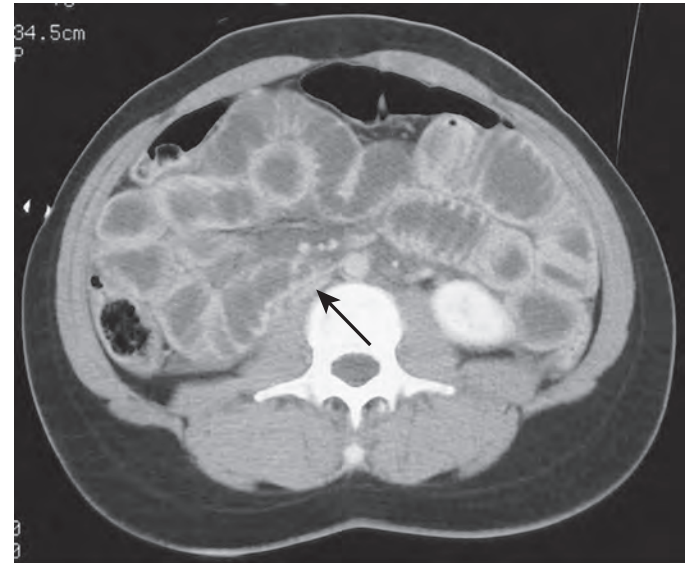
Shock bowel in a 23-year-old woman immediately after a motor vehicle accident. Contrast-enhanced CT demonstrates pneumoperitoneum, a flattened IVC (arrow) suggestive of hypovolemia, and a diffusely thickened, avidly enhancing small bowel. This constellation of findings represents the shock bowel complex.
